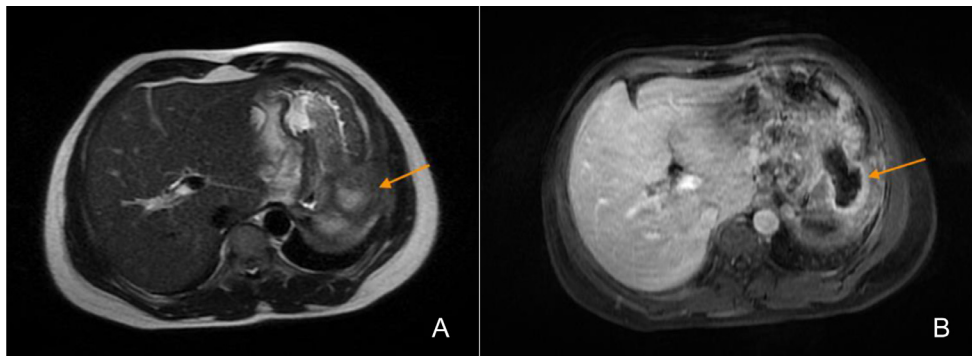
MRI demonstrating the mass that shows heterogeneous high signal intensity on T2-weighted images (A) and homogeneous low signal intensity on T1 weighted images with a mildly enhancing wall after injection of gadolinium (B).
